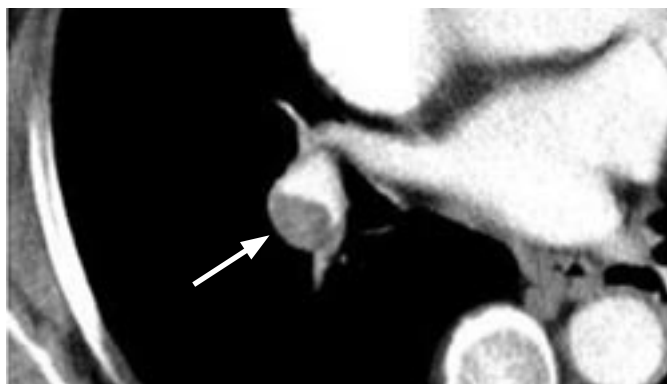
Axial CT image shows a hypodense filling defect (white arrow) in the right lower lobe branch of the right pulmonary artery.
